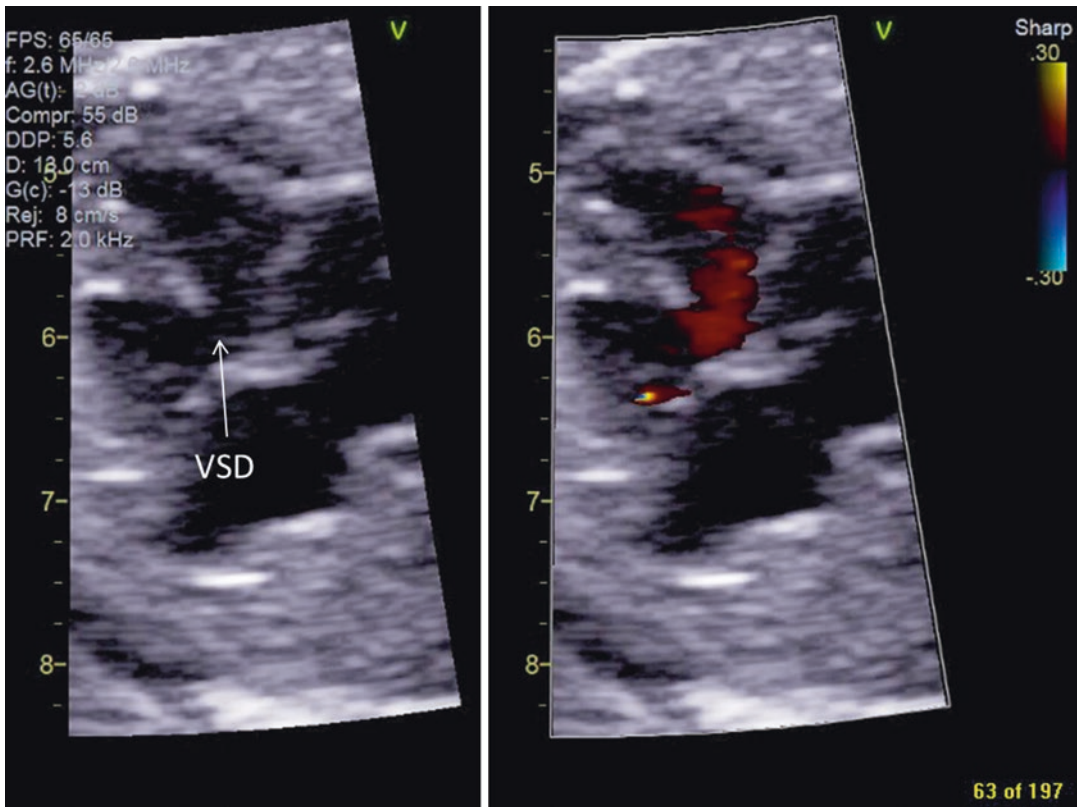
2D and color Doppler four-chamber view demonstrating VSD with shunting across the ventricular septum
